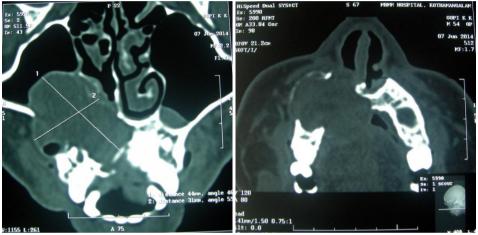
CT scan showed soft tissue mass in the right hard palate with destruction of hard palate, pterygoid plates, lateral wall of nose and floor of maxillary sinus.
